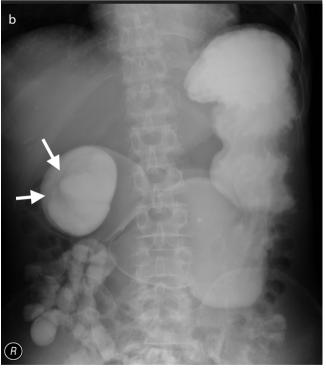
a, b. Abdominal x-ray of the patient revealed a distended stomach with food debris (a); an upper GI series study of the patient suggested an obstructive lesion in the duodenal bulb (b) (arrows).
